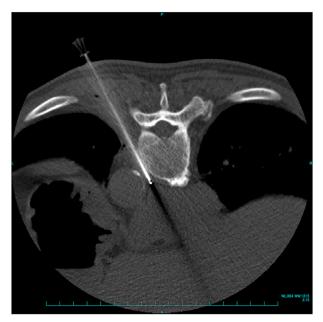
Comparison of CT before and after normal saline injection. (A) Prebiopsy CT showed the azygos vein (arrow). (B) Following the injection of normal saline through the side hole of the blunt-tip stylet, CT revealed an enlargement of the mediastinal space and lateral deviation of the azygos veins.
